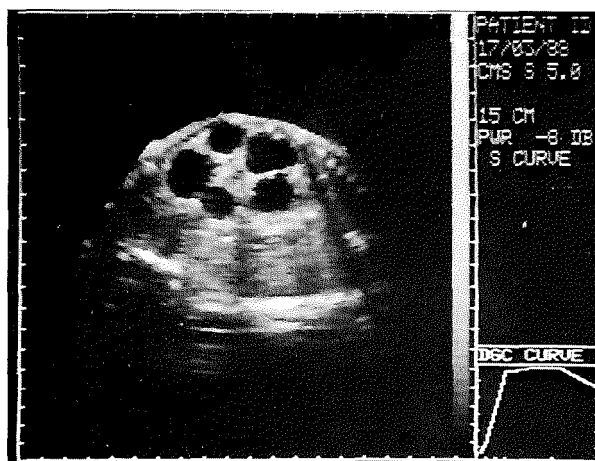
Ultrasonic picture of a multicystic kidney in a fetus of a gestational age of 26 weeks
